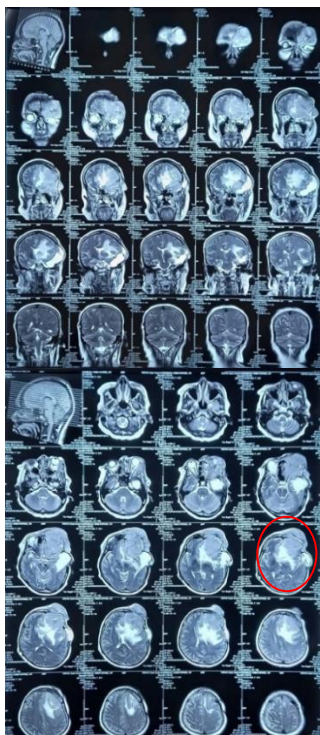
MRI of the patient before operation
